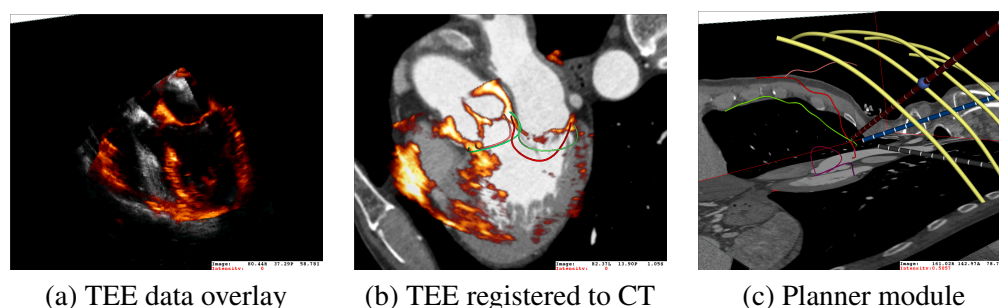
Perioperative heart shift: a) overlay of TEE data showing initial heart location (gray) with post chest insufflation (hot metal); b) overlay of initial TEE data with preoperative CT data; c) all data loaded in a peri-operative planner, including original and shifted coronary artery locations (red and green splines).
